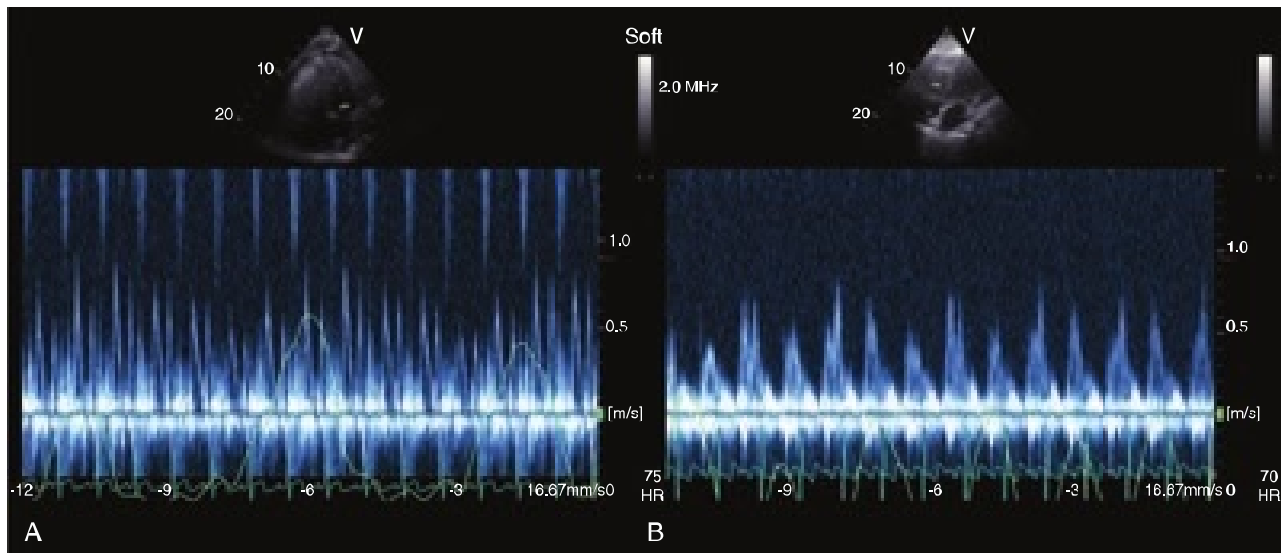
Apical four-chamber view on transthoracic echocardiography with Doppler interrogation across the mitral (A) and tricuspid (B) valves. A large variability during respiration can be seen in both inflow patterns, suggesting the presence of tamponade.
